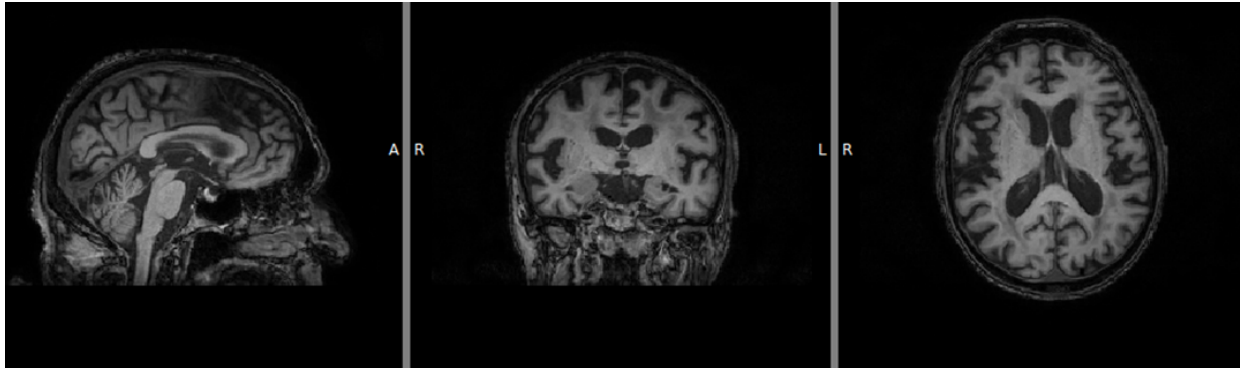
Example of slices of the MRI data from subject f4395. Left column: Coronal plane. Middle column: Sagittal plane. Right column: Transverse plane.
